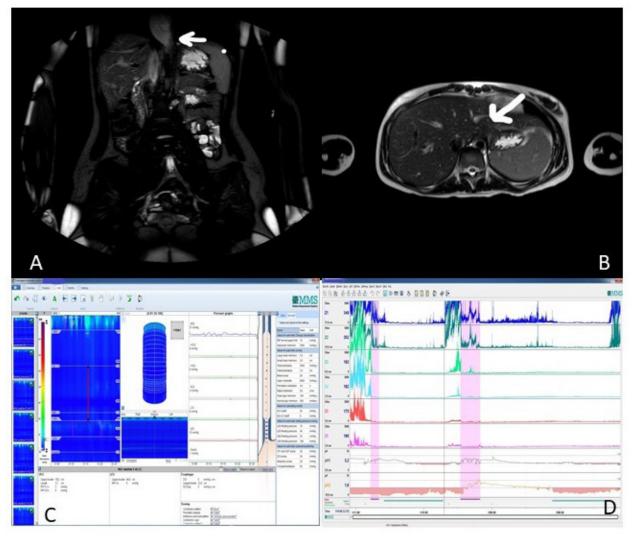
A) MRI immage in aksial projection with signs of esophageal dilatation and esophagogasttric junction stenosis; B) MRI immage in sagital projection with no signs of esophageal muscular englargement in lower esophagus; C) Esophageal manometry finding in one of ten swallows with absent peristaltic activity. The absent peristaltic activity is presented with blue colour on immage (left) what represents low pressure and in the cumulative curves (on the right side); D) Results of 24h impedance pH measurement. The continuous acid reflux dominantly in lower esophagus and significant in the middle esophagus (lowert two curves- the red color iz atributed to pH < 4). The continuous impedance activity in edophagius (first six curves).
